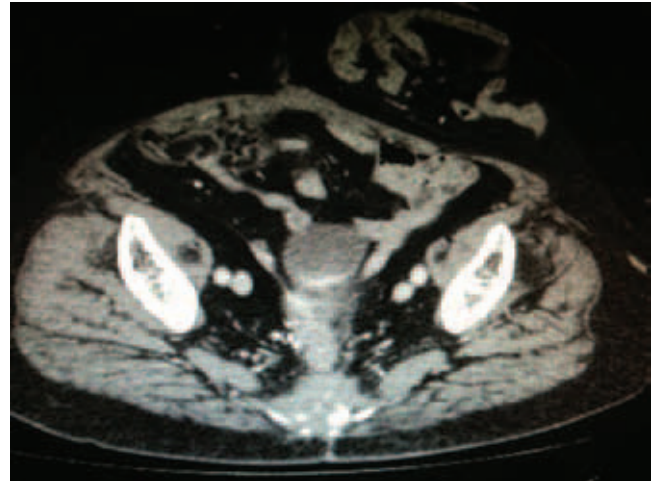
CT - axial view - presacral tumor lesion.
